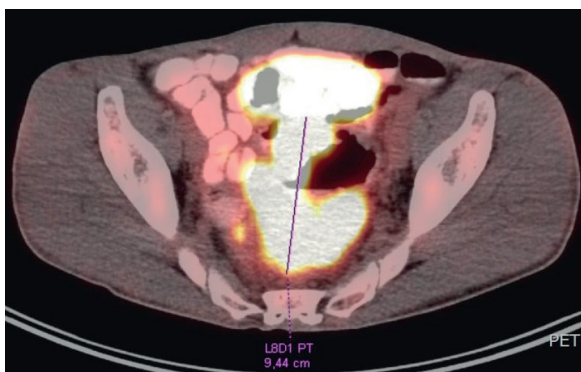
A 49-year-old male with melanoma (pT1N0M1c); a PET scan, a transverse view – a rectosigmoid tumor involving the rectovesical space, 94 × 71 × 67 mm (AP × TR × CC), standardized uptake value (SUV): 11.1
